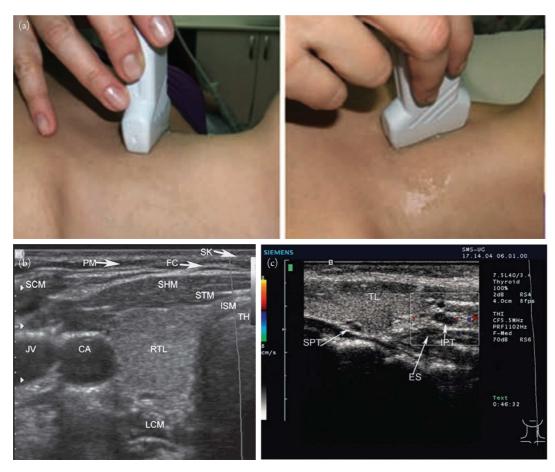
(a) Scanning technique for examination of the thyroid. (A) Transverse view of the thyroid. (B) Longitudinal section of the right thyroid. Adapted from Figures 1a and 1b of Ghervan C. Thyroid and parathyroid ultrasound. *Med Ultrason*. 2011;13(1):80–84. (b) Transverse view of the right thyroid. SK = skin, PM = platisma muscle, FC = fascia cervicalis, SHM sternohyoid muscle, STM = sternothyroid muscle, SCM = sternocleidomastoid muscle, ISM = isthmus, TH = trachea, RTL = right thyroid lobe, JV = jugular vein, CA = carotid artery, ESP = esophagus, LCM = longus colli muscle. Adapted from Figure 2 of Ghervan C. Thyroid and parathyroid ultrasound. *Med Ultrason*. 2011;13(1):80–84. (c) *Longitudinal view of normal parathyroid glands*. Color Doppler is used to help differentiate glands from vasculature structures. TL = thyroid lobe, SPT = superior parathyroid gland, IPT = inferior parathyroid gland, ES = esophagus. Adapted from Figure 9 of Ghervan C. Thyroid and parathyroid ultrasound. *Med Ultrason*. 2011;13(1):80–84.
